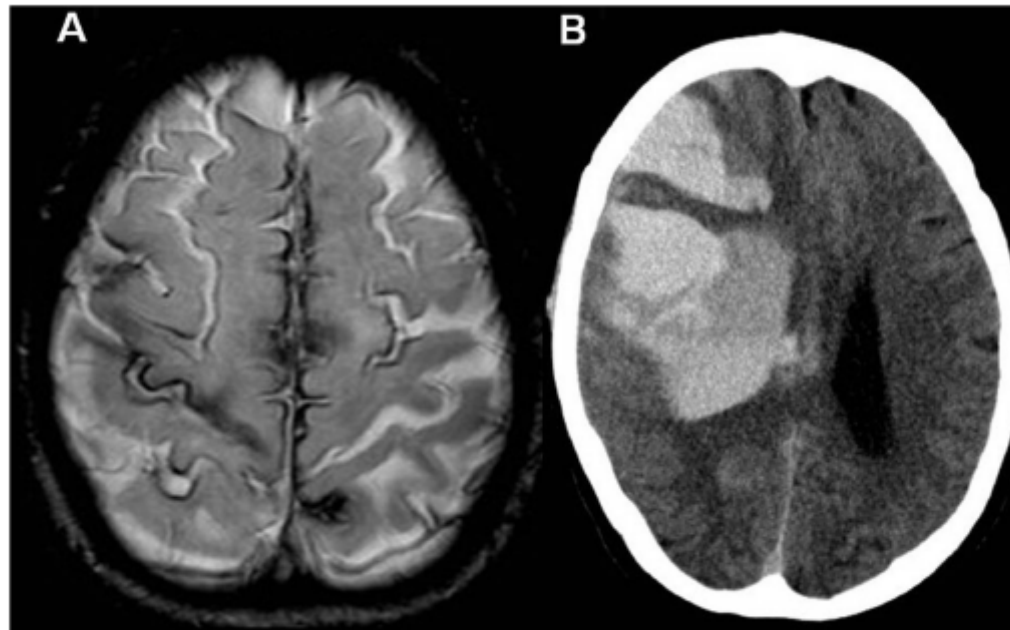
(A) MR scan of brain from an 82-year-old woman who presented with recurrent episodes of sudden onset seizures affecting the face, gum and hand, with facial drooping, lasting about 20 min. The patient was treated with clopidogrel. (B) CT scan of head following admission 1 month later with sudden left haemiparesis. Note large right frontal intracerebral haematoma.
